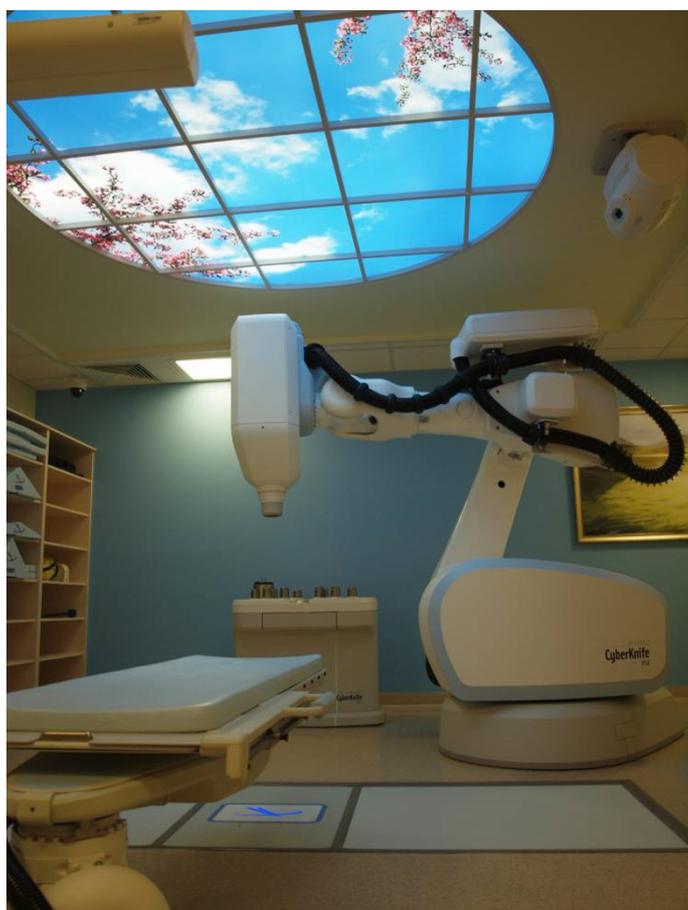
Biomedical accelerator [A] for VMAT technique, equipped with a high-resolution multileaf collimator, [B] - CyberKnife equipped with wheel collimators. Both accelerators generates photon radiation (X-6 MV) and are equipped with the X-ray imaging. Despite the technical differences, these accelerators, are perfectly suited to the stereotactic radiosurgery implementation.
